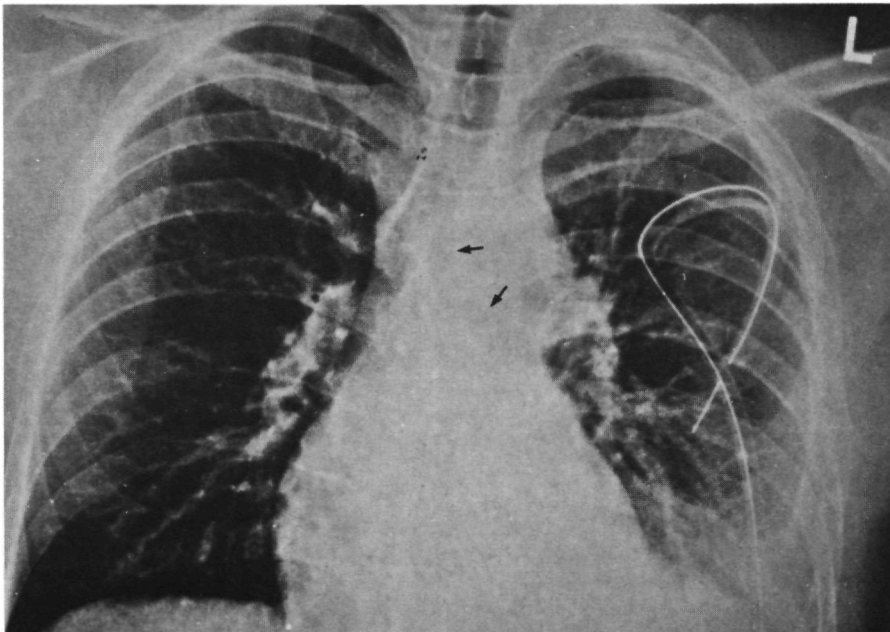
15 Combination of aortic rupture and diaphragmatic rupture. Chest X-ray: widening of the mediastinal shadow (9 cm) and unsharp aortic contour. Contusion of the left lung. Opacified pulmonary window. No displacement of trachea or nasogastric tube. Left hemi-diaphragm not visible. Patient (male, 60 years, car-driver) died from unrecognised TAR, while diaphragmatic repair was performed.
